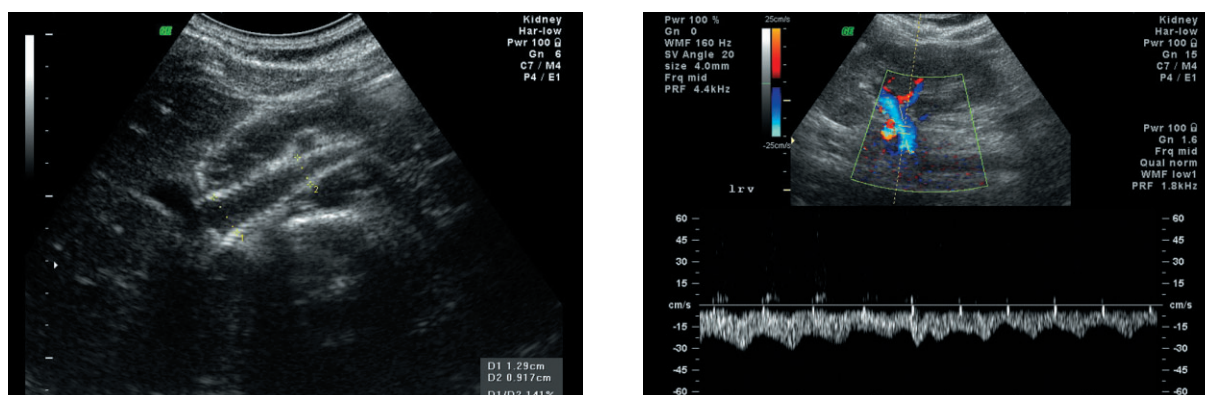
Control postoperative USG – an expanded stent in the left renal vein. In Doppler sonography water outflow through the left renal vein visible.
